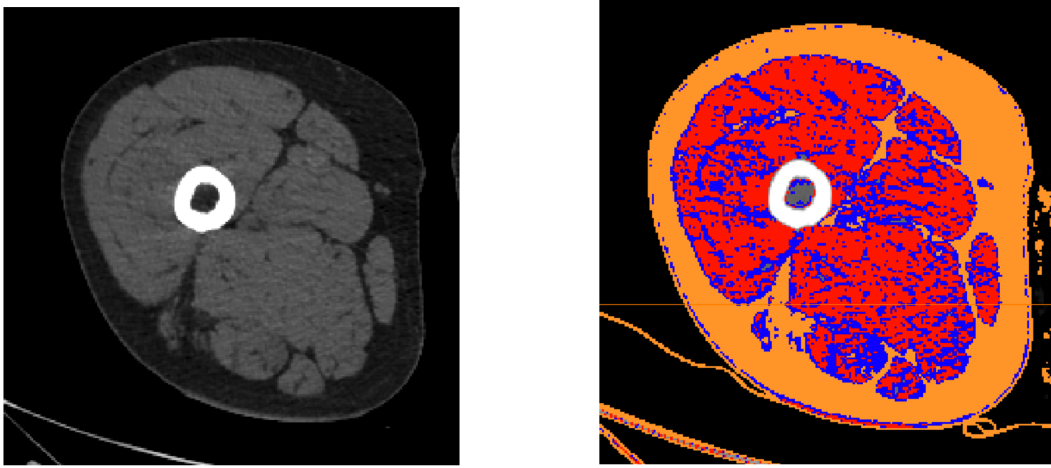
Mid-thigh CT Scan from the AGES data-set: on the right fat is orange, muscle is red and connective tissue is blue
